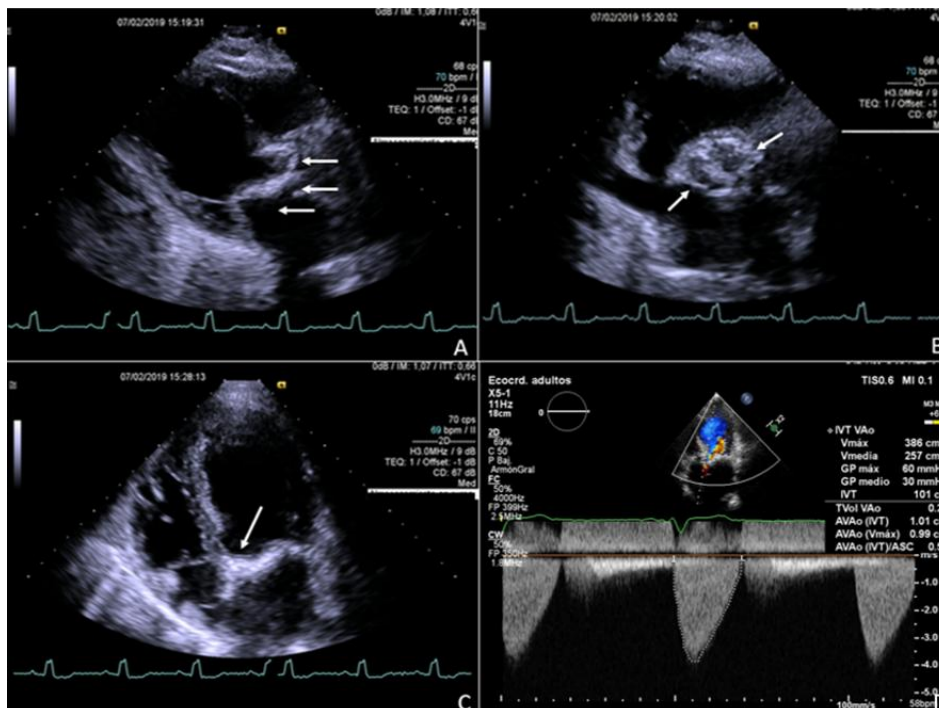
Transthoracic echocardiogram shows severe thickening and calcification of the aortic root, aortic valve, aorto-mitral curtain and the anterior mitral leaflet (arrows) on Long axis parasternal view (A), Short axis parasternal view (B) and Apical 4 Chambers view (C). Continuous-wave Doppler mode on the Apical 5 chambers view, reveals aortic regurgitation and an increased gradient across the aortic valve, with peak velocity near 4 m/s (D).
